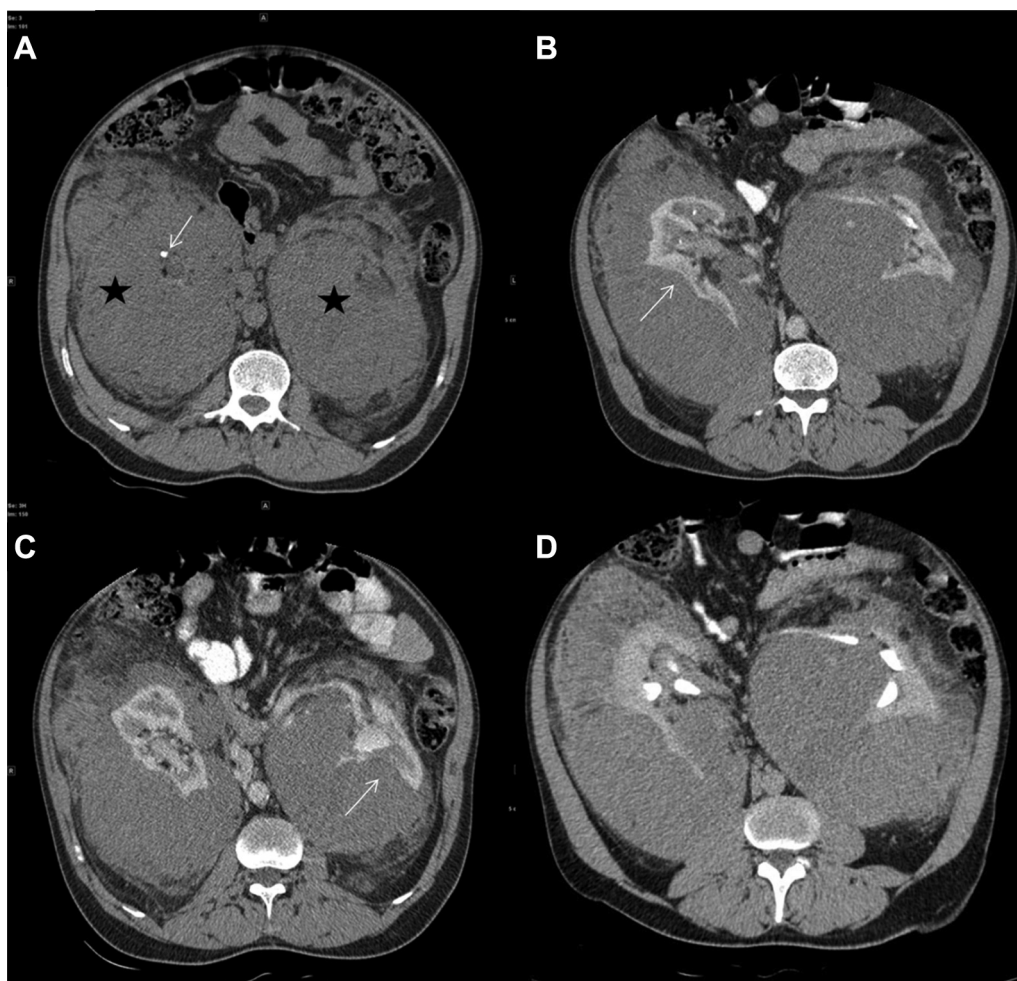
A 54-year male patient with perirenal fibromatosis, axial CT scan (A) noncontrast CT axial CT sections at interpolar region of kidney—homogeneous soft-tissue masses (asterisk) in bilateral lumbar region indistinguishable from the kidneys, tiny calyceal calculi (white arrow). (B) Contrast-enhanced arterial phase—bilateral perirenal space homogeneous well-defined masses with renal cortical scalloping (white arrow). Renal parenchymal thinning and distortion are seen. Small and large bowel loops displaced anteriorly. (C) Corticomedullary phase—normal renal parenchymal enhancement. (D) Excretory phase—normal excretion in both kidneys evident by pelvicalyceal system opacification. Minimal prominence of the pelvicalyceal system noted on either side.
